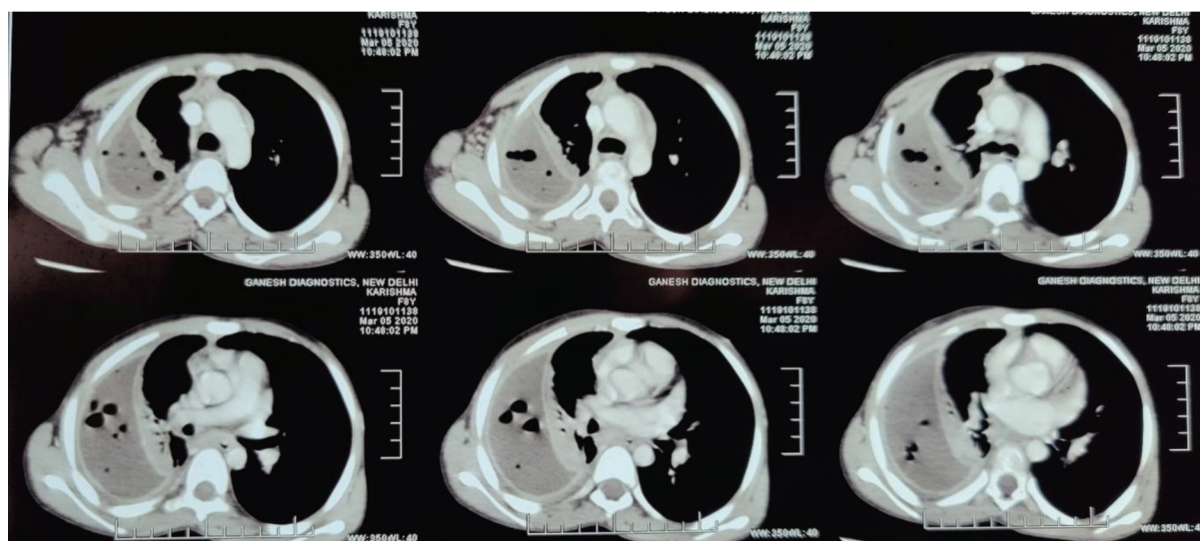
Axial Section of CT scan left side Empyema Thoracis
